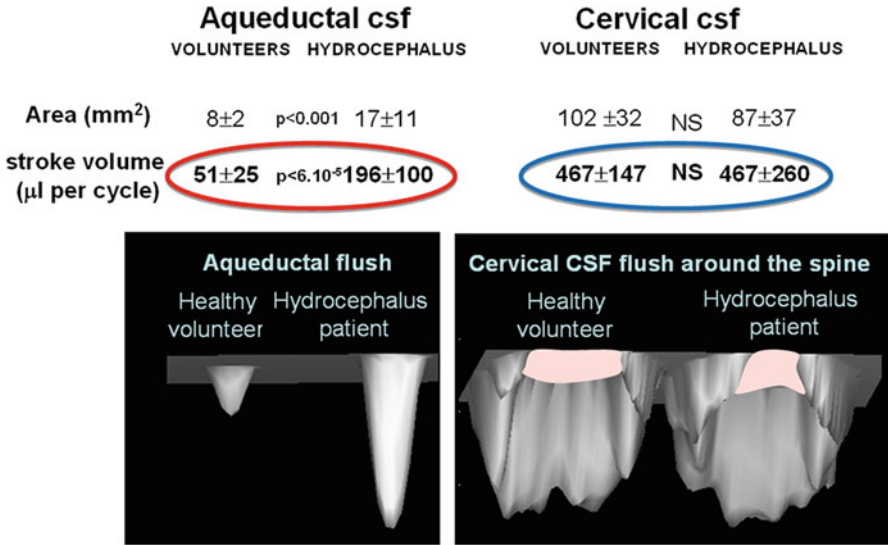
CSF flows in communicating hydrocephalus population studied using PC-MRI
